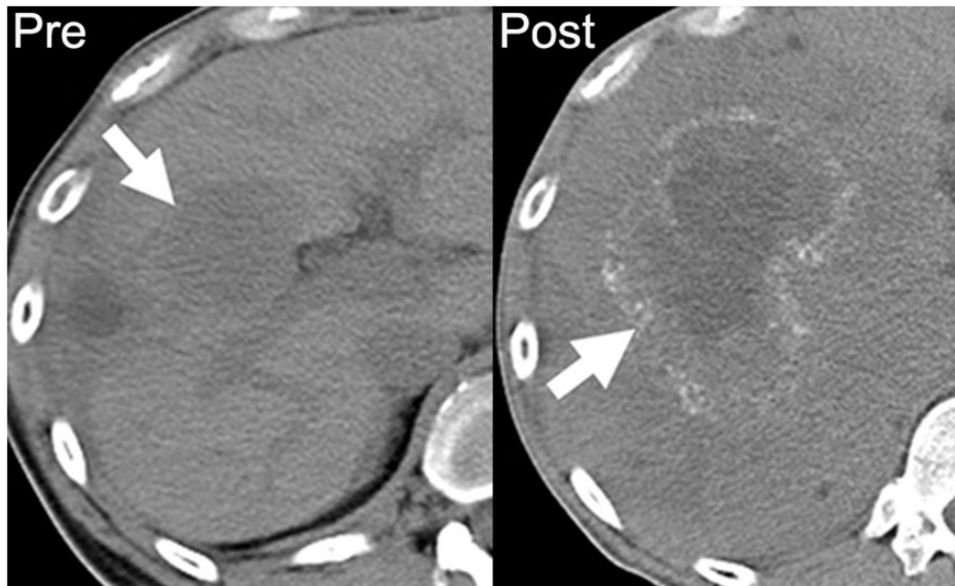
A 39-year-old man with metastatic mucinous adenocarcinoma of the distal sigmoid colon. Axial noncontrast CT image performed before chemotherapy demonstrates a noncalcified hypodense hepatic metastasis (arrow on left). After 18 months of chemotherapy on multiple regimens, there is an increase in the size of the right hepatic metastasis with a rim of amorphous calcification (arrow on right).
